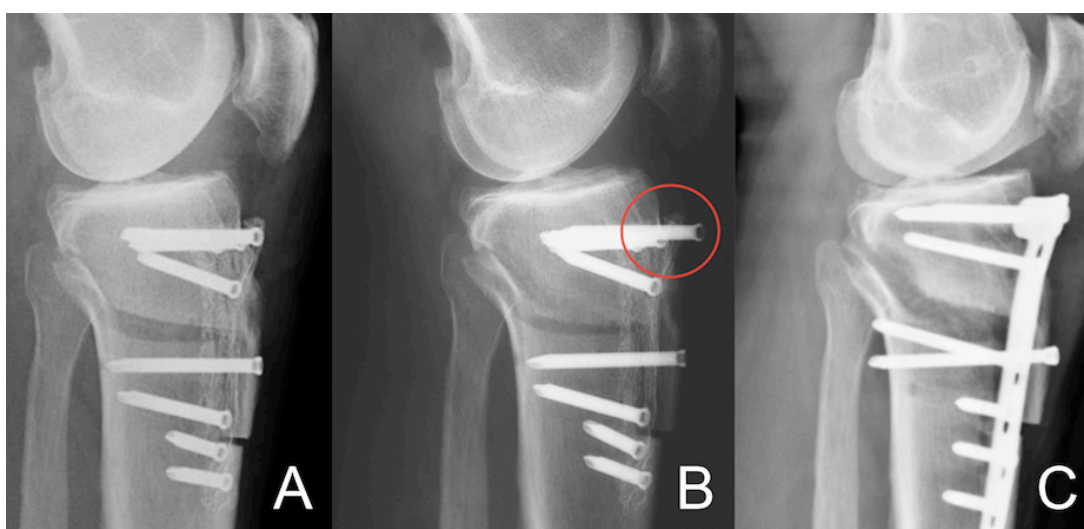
Postoperative lateral radiograph at the inpatient stay show a regular fixation of ow HTO with the 1st generation PEEKPower HTO-Plate® in a 52 year old patient (A). Postoperative lateral view 4 weeks after surgery show screw loosening (red circle) of one of the most proximal screws with subsequent loss of correction after a fall with twisting of the lower limb (B). Postoperative lateral radiograph at the inpatient stay show successfully revised ow HTO with the TomoFix™ plate (C). In this patient, removal of the TomoFix™ plate within complete consolidation of the osteotomy gap was done 14 months after initial ow HTO.
